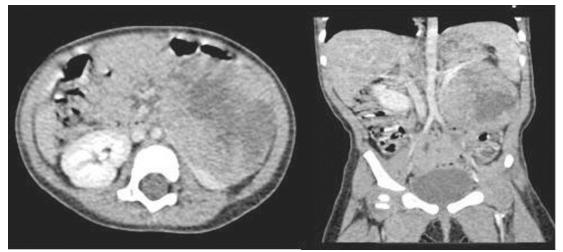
Whole abdominal CT scan showing a 7cm x 6cm mass occupying mid to inferior pole of left kidney, (Right) axial cut, (Left) coronal cut.
